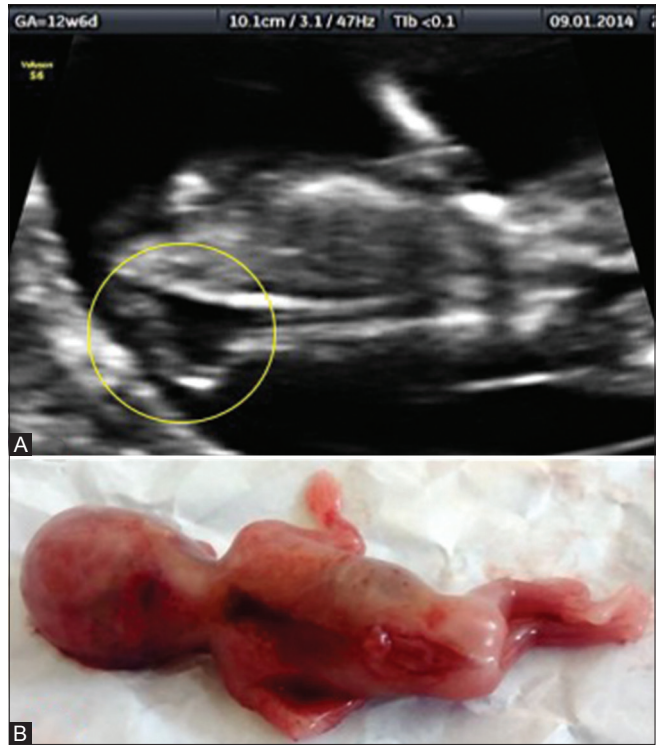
Ultrasound image of mid-sagittal section of fetal head where IT is not clear
